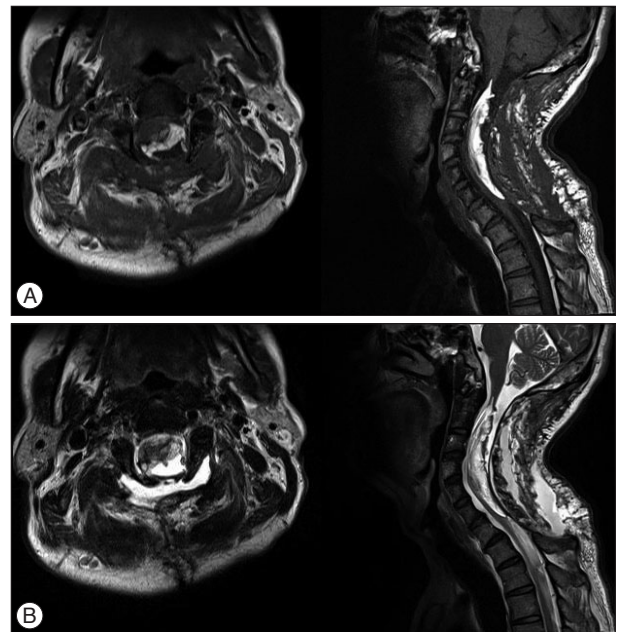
Preoperative T1- (A) and T2- (B) weighted MRI images at the time of the second operation show an intradural lipoma from the C2 to C7 level exhibiting high signal intensity, suggesting a regrown lipomatous mass.
